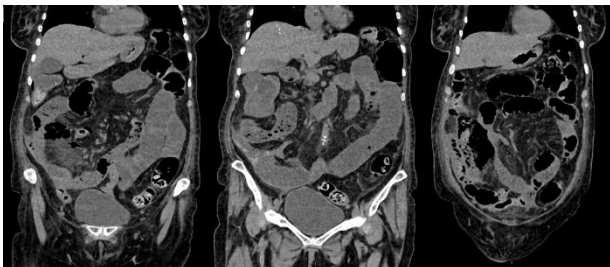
Non-contrast computed tomography image demonstrating intra-abdominal pathology consistent with acute abdomen. The scan reveals evidence of free intraperitoneal air and localized fluid collections, suggestive of intestinal perforation.
